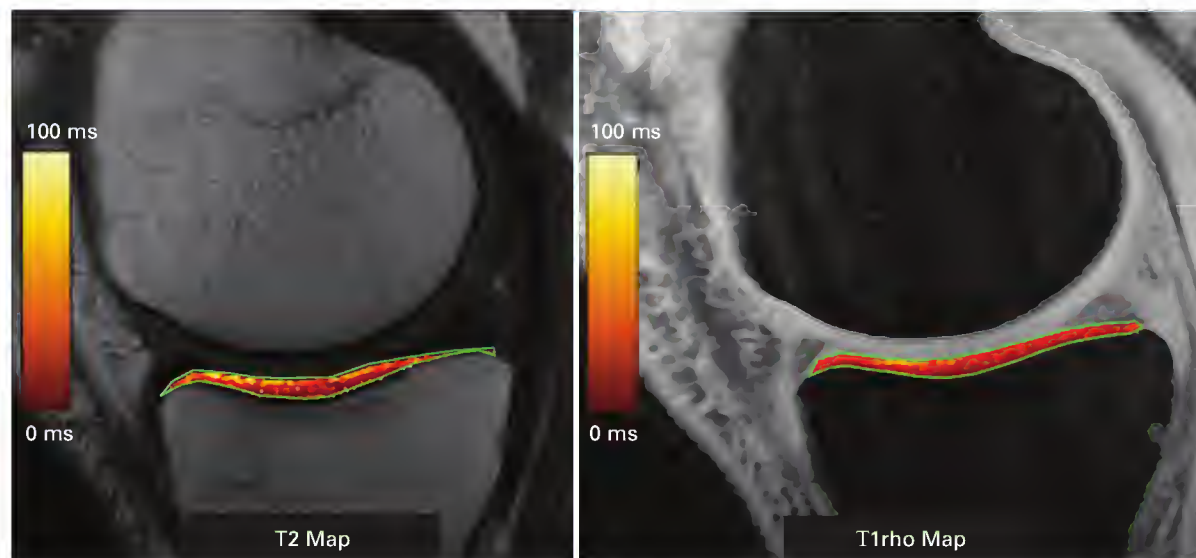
Measurements of tissue physiology with magnetic resonance imaging T2 map (left) and T1rho map (right) of the tibial cartilage in a healthy volunteer. The color scale shows relative relaxation time values between 0 and 100 ms. Changes in T2 relaxation time are correlated with collagen matrix status; changes in T1rho are correlated with proteoglycan content.
